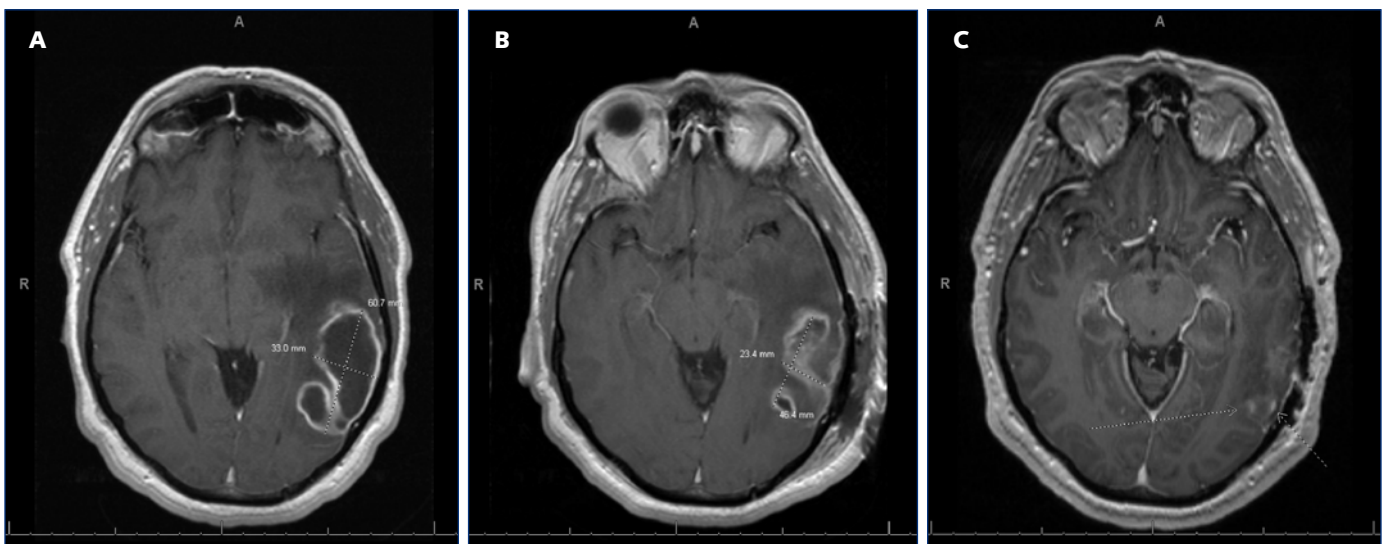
Brain MRI images at presentation (A: T1 FLAIR), after craniotomy (B: Contrast-enhanced T1), and at 6-week follow-up (C: Contrast-enhanced T1 MP-RAGE).
